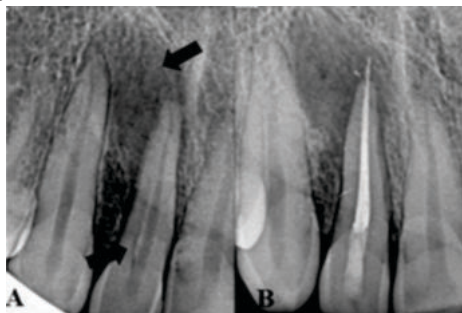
Preoperative radiograph (A) showing parapaternal line and pear shaped radiolucency and Postoperative radiograph (B).
